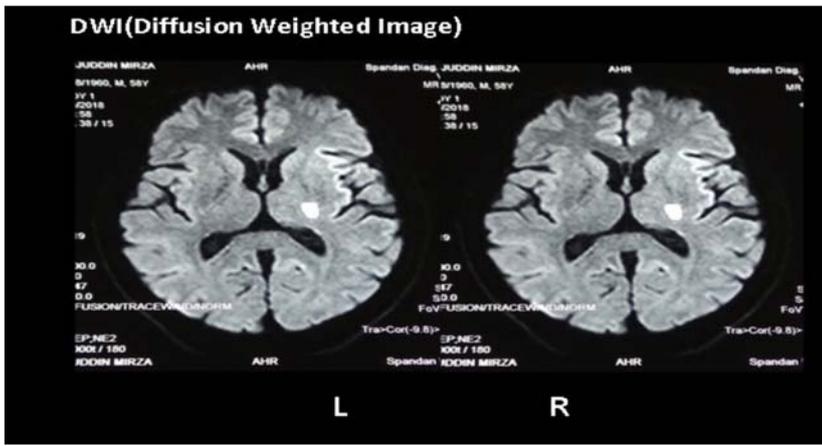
A Diffusion Weighted Magnetic resonance image of a 58 year old man with a left putaminal infarct extending to the left thalamus region left posterior limb of internal capsule, adjoining areas of globus pallidus externa. L=left hemisphere; R= right hemisphere
